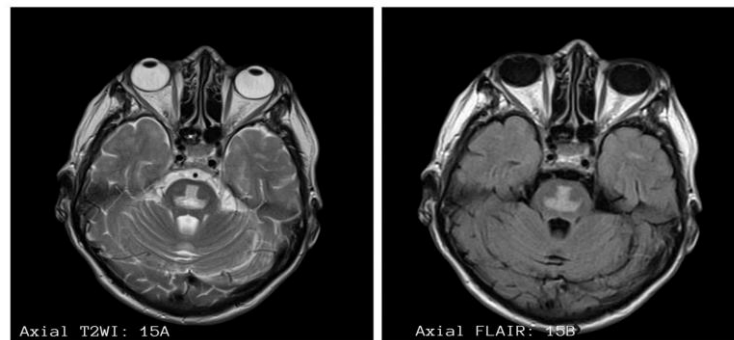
Images from a subject with diagnosed osmotic demyelination showing typical trident sign on T2WI and FLAIR sequences.
